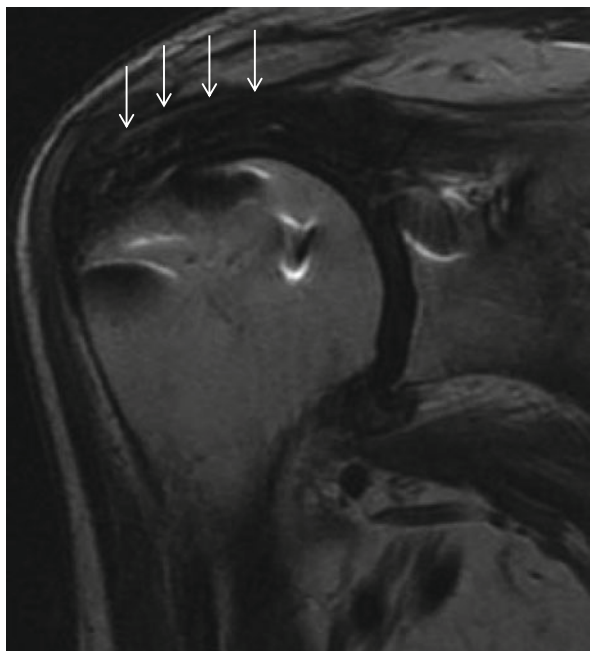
Magnetic resonance imaging (MRI) findings 3 months after superior capsule reconstruction. When all fatty tissue on the graft was removed, T₂-weighted MRI showed that the graft area was of low intensity (*white arrows*)
